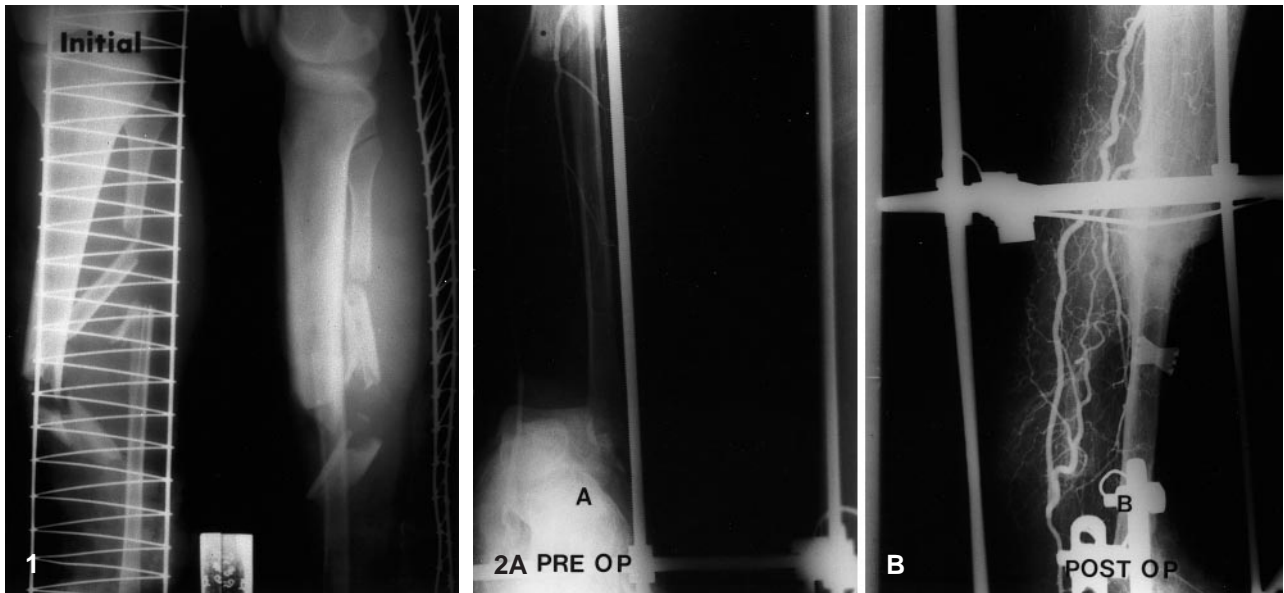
Radiographs of the right tibia and fibula of a male aged 20 years after a severe open fracture. A defect of nearly 17 cm is present in the tibia
